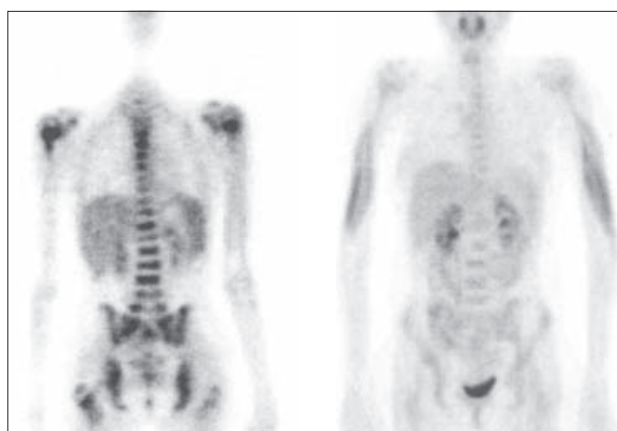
Db.  $^{18}\text{F}$ FDG-PET during treatment.
